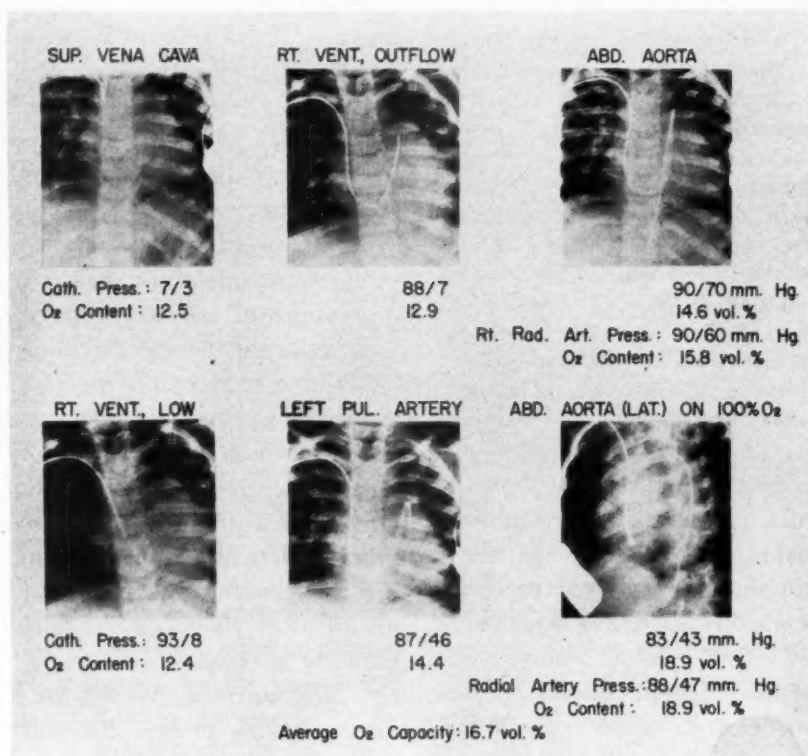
Findings at the time of ventricular catheterization in Case 2. "Cath. Press." indicates the pressure in millimeters of mercury as obtained at the point where the tip of the catheter lay at the time the accompanying roentgenogram was made. "O<sub>2</sub> Content" refers to the number of cubic centimeters of oxygen contained in 100 cc. of blood.
